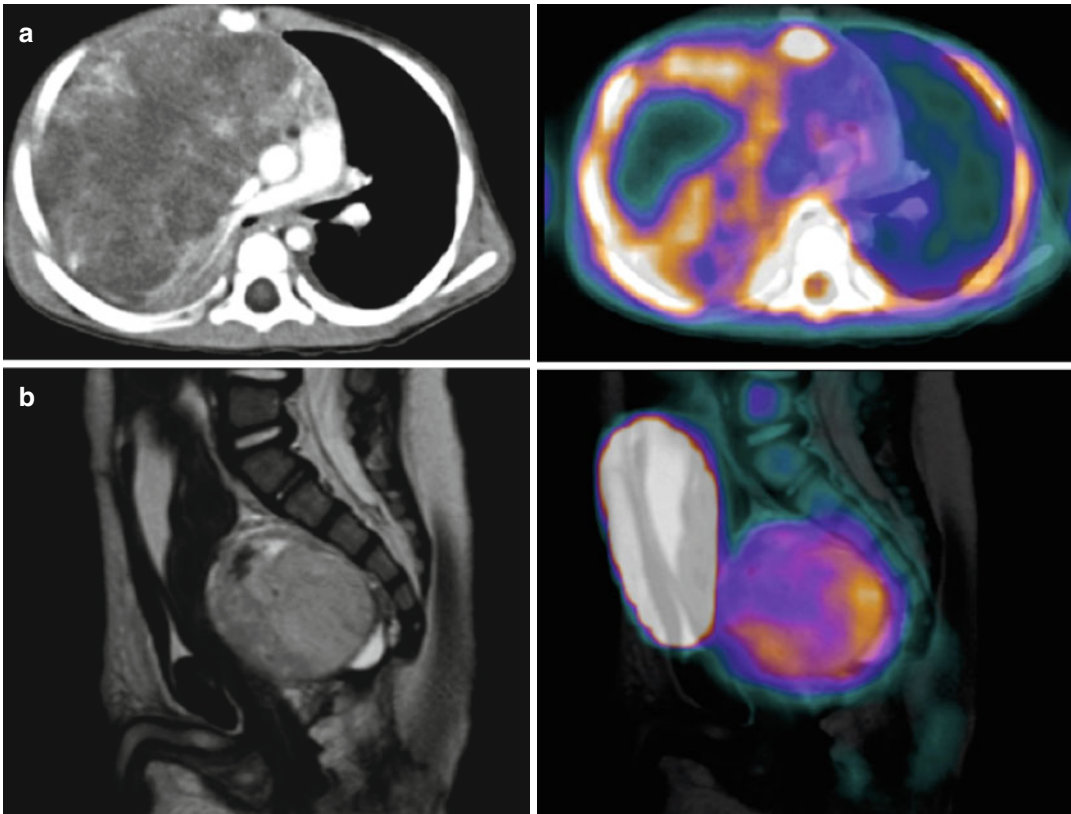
(a) Mediastinal yolk sac tumor. A 2-year-old male presented with a cough and increasing respiratory distress. CXR and CT scan showed a large mediastinal mass with areas of necrosis and a pleural effusion. Biopsy showed yolk sac tumor. The ^{18}F -FDG PET/CT scan was performed after 5 days of chemotherapy. There is increased metabolic activity peripherally in the viable tumor with minimal uptake in large areas of necrosis. No metastatic
